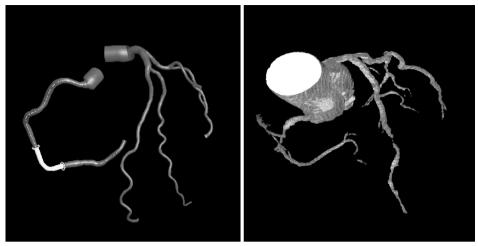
The left panel shows the coronary tree as extracted from MSCT by the Philips 3DCA system while the right panel shows the vessels extracted directly from CT by the Siemens package. See this figue in color in the Appendix page 379.
